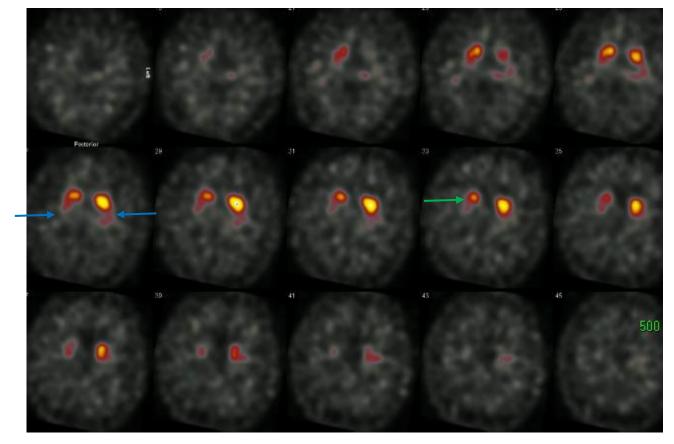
Axial SPECT images from DaT Scan
